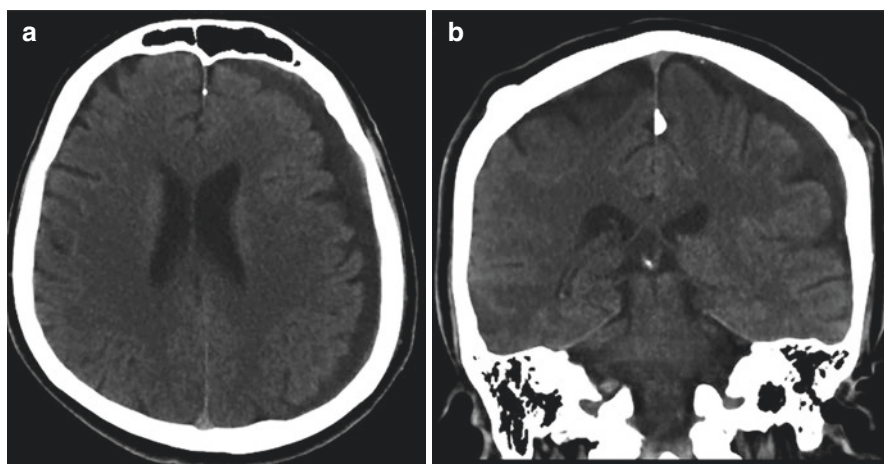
A 60-year-old male patient; on reformatted CT images in axial (a) and coronal planes (b), a crescent-shaped, extra-axial hypodense collection (classical chronic subdural hematoma) is observed in the left frontoparietal region
